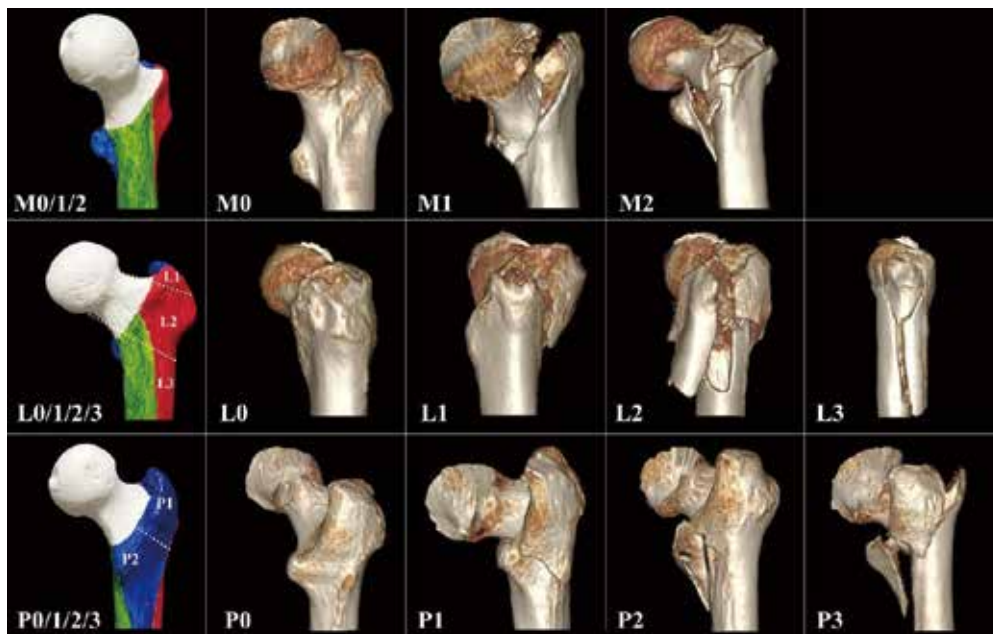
Actual images of three-dimensional computed tomography (3D-CT) in each subtype. A intertrochanteric fracture is characterized as  $M_{0/1/2}L_{0/1/2/3}P_{0/1/2/3}$ . M, medial column (Green area) ;  $M_0$ , intact wall ;  $M_1$ , simple fracture ;  $M_2$ , multifragmentary fracture. L, lateral column (Red area) ;  $L_0$ , intact wall ;  $L_1$ , proximal portion fracture ;  $L_2$ , intermediate portion fracture ;  $L_3$ , distal portion fracture. P, posterior column (Blue area) ;  $P_0$ , intact wall ;  $P_1$ , GT fracture ;  $P_2$ , LT fracture ;  $P_3$ , GT + LT fracture.
